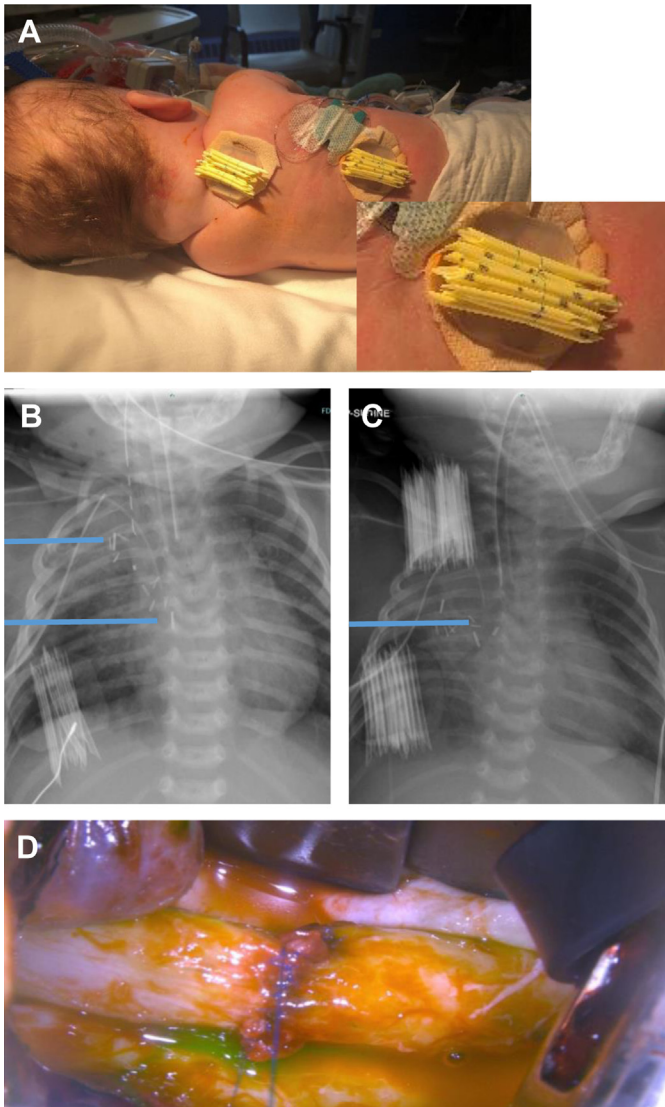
External traction process for LGEA. (A) Traction sutures are brought out through the skin and tied to a silicone disk. Tension is transmitted to the esophageal segments by adding feeding tube fragments under the sutures. (B) Radiopaque clips on the traction system and the esophageal wall are tracked on plain radiographs until (C) the clips cluster together at which point esophago-esophageal anastomosis (D) is performed.
